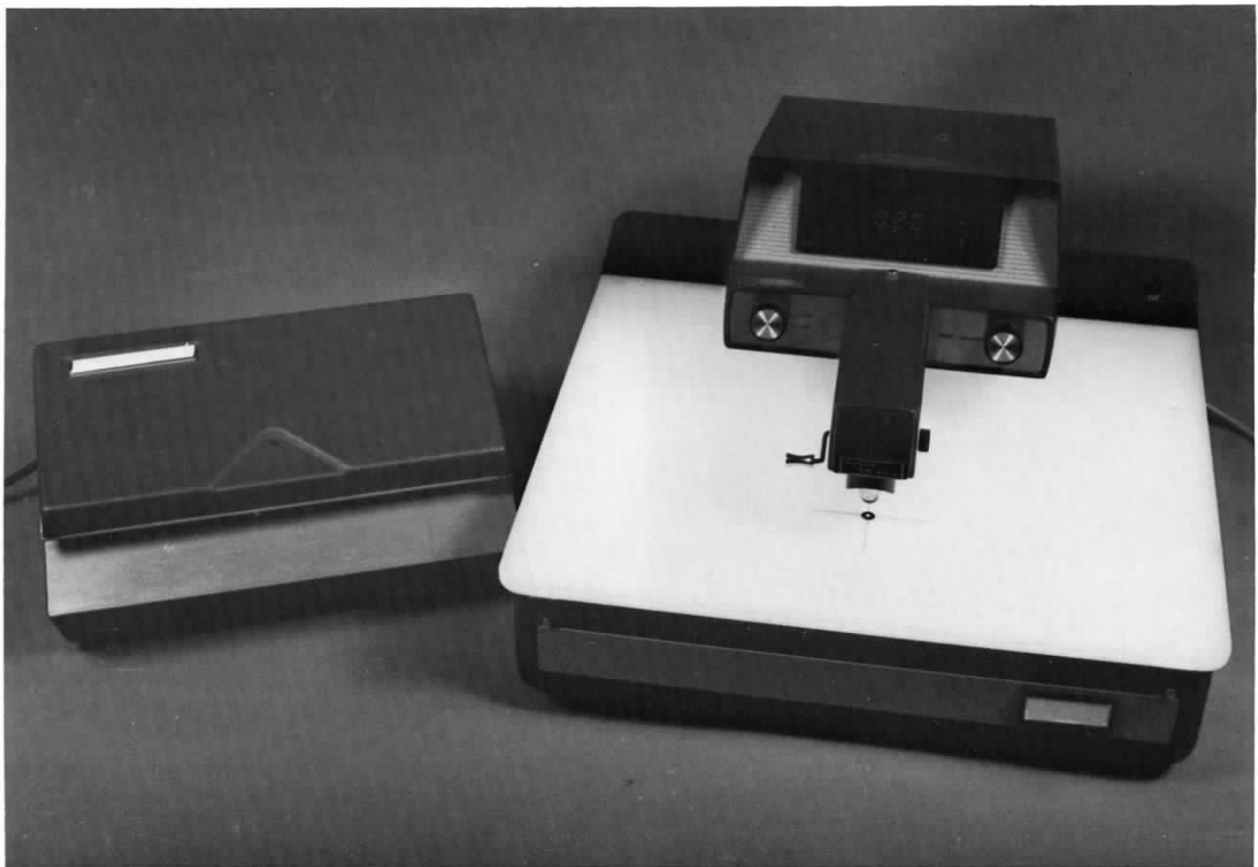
A sensitometer (*left*) and densitometer (*right*) are essential for a photographic quality control program. Densitometers with a built-in light source are preferred. The color of the light used for quality control purposes in either the sensitometer or densitometer does not matter. However, sensitometers should *never* be used to compare different radiographic films since such comparisons are only meaningful if the film is exposed with the *exact* type of light with which it is used clinically, i.e., screen light emitted from the appropriate intensifying screens.
